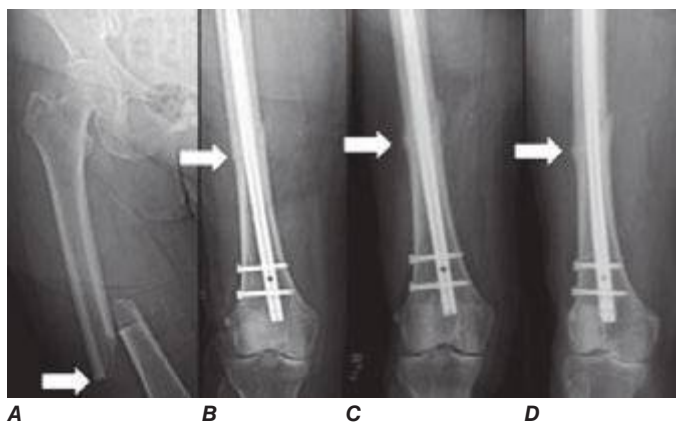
An atypical femur fracture (AFF) of the femoral diaphysis. A. Note the transverse fracture line in the lateral cortex that becomes oblique as it progresses medially across the femur (white arrow). B. On radiograph obtained immediately after intramedullary rod placement, a small area of periosteal thickening of the lateral cortex is visible (white arrow). C. On radiograph obtained at 6 weeks, note callus formation of the fracture site (white arrow). D. On radiograph obtained at 3 months, there is a mature callus that has failed to bridge the cortical gap (white arrow). Note the localized periosteal and/or endosteal thickening of the lateral cortex at the fracture site (white arrow). (From E Shane et al: *J Bone Min Res* 29:1-23, 2014. Courtesy of Fergus McKiernan.)
